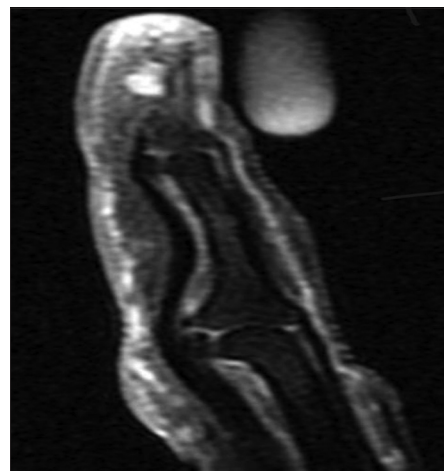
MRI of the right index done at our center.
